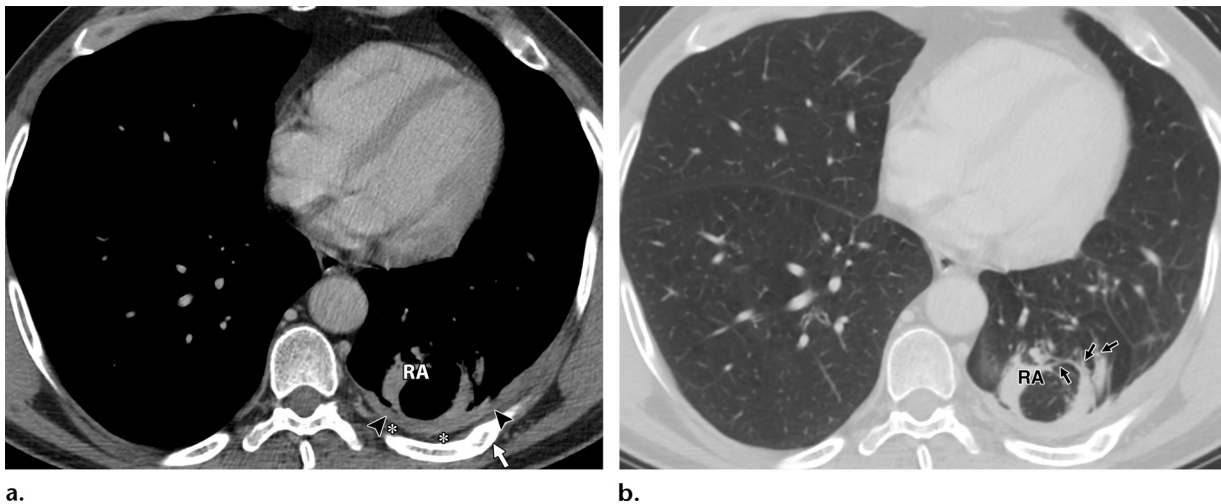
Rounded atelectasis (RA) with associated pleural thickening and extrapleural adipose tissue thickening. (a) Axial chest CT image obtained in the mediastinal window through the lower region of the chest shows rounded atelectasis, increased extrapleural adipose tissue (*), and pleural thickening (arrowheads). (b) Axial chest CT image obtained in the lung window through the same region shows a loss of volume of the left lower lobe and architectural distortion of the lung that surrounds the rounded atelectasis. This distortion results in the classic comet tail sign, which is caused by the traction of vessels and bronchi (arrows) that surround a masslike area of rounded atelectasis. The bronchovascular bundles appear to be pulled by the mass and resemble a comet tail. A rib fracture (arrow in a), which caused a hemothorax that resulted in the depicted pleural changes, has healed.
